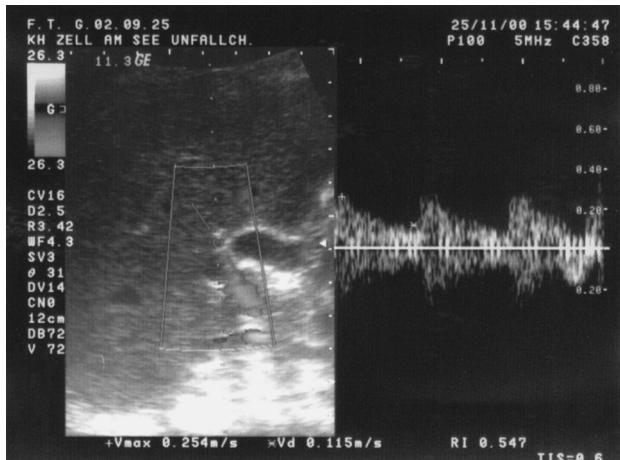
Ultrasound of the liver (eight years after operation) shows a normal spectrogram and a normal Resistance-Index of the right hepatic artery
